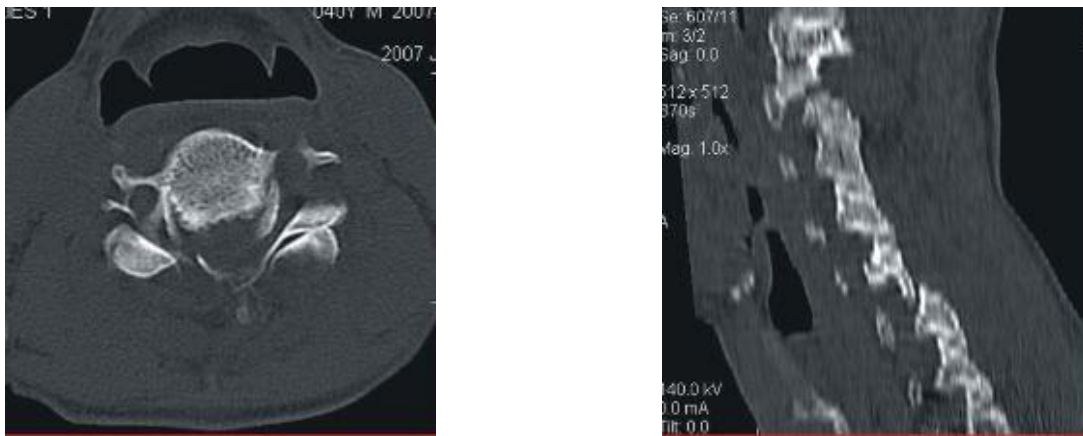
CT cervical spine axial (1a) and sagittal (1b) views showing unilateral left C5-C6 facet joint locking
